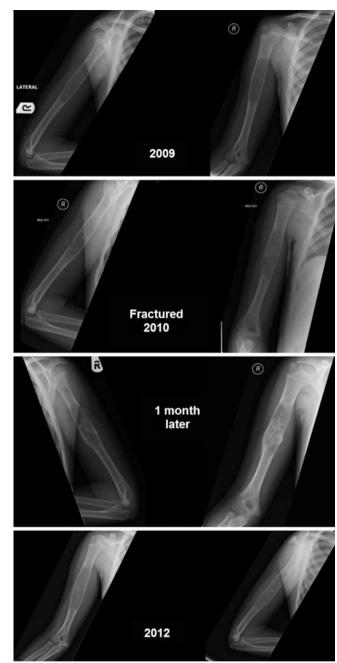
This young boy was treated non-operatively for simple bone cyst. He had a pathological fracture in January 2010. After a month, plain x-ray showed the cyst was filling with bone; however, the cyst was larger after a year (see also Fig. 43.7)
